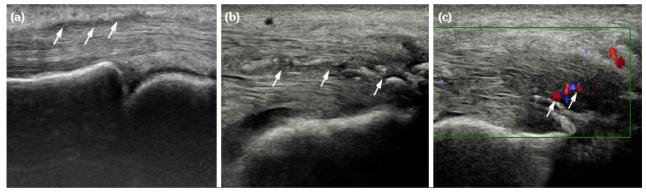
Two-dimensional and energy Doppler ultrasound images of SNRA and SPRA tenosynovitis and tendinitis. (a) A 33-year-old female patient diagnosed with SPRA, exhibiting a small lamellar echoless area in the left hand middle finger flexor tendon sheath considered as tenosynovitis (indicated by the arrow); (b, c) A 39-year-old male patient diagnosed with SNRA, showing thickening of the right Achilles tendon (indicated by the arrow in [b], uneven internal echo, and multiple spot-like strong echo, indicative of Achilles tendinitis (indicated by the arrow in [c]).
